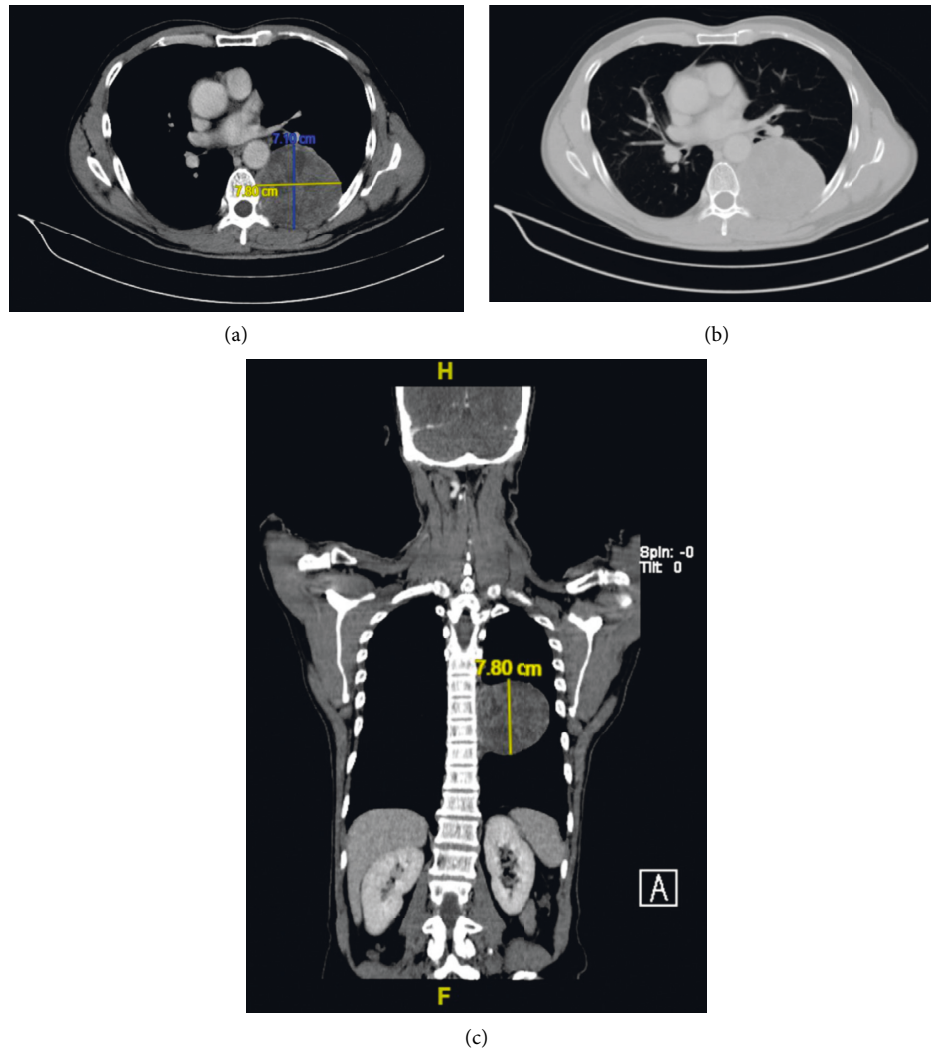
CT showing a well-defined heterogeneously enhancing mass at the left paravertebral region with extension into left T7/8 neural foramina. (a)-(b) Axial view; (c) coronal view.
